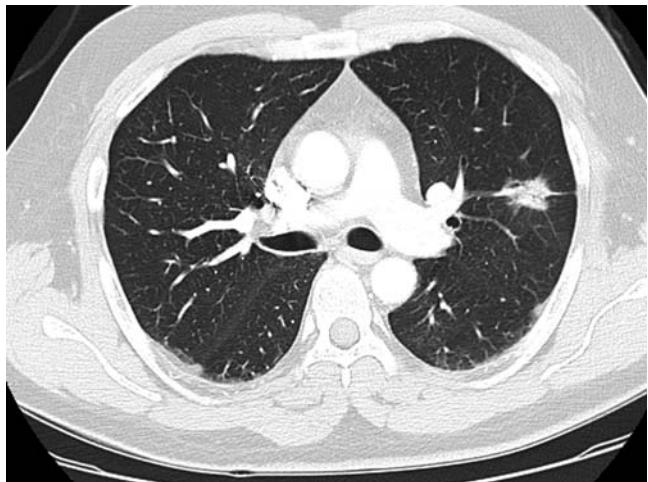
CT of chest. Note mass lesion presenting as a spiculated mass of the left upper lobe. Biopsy showed an acinar type of adenocarcinoma.
